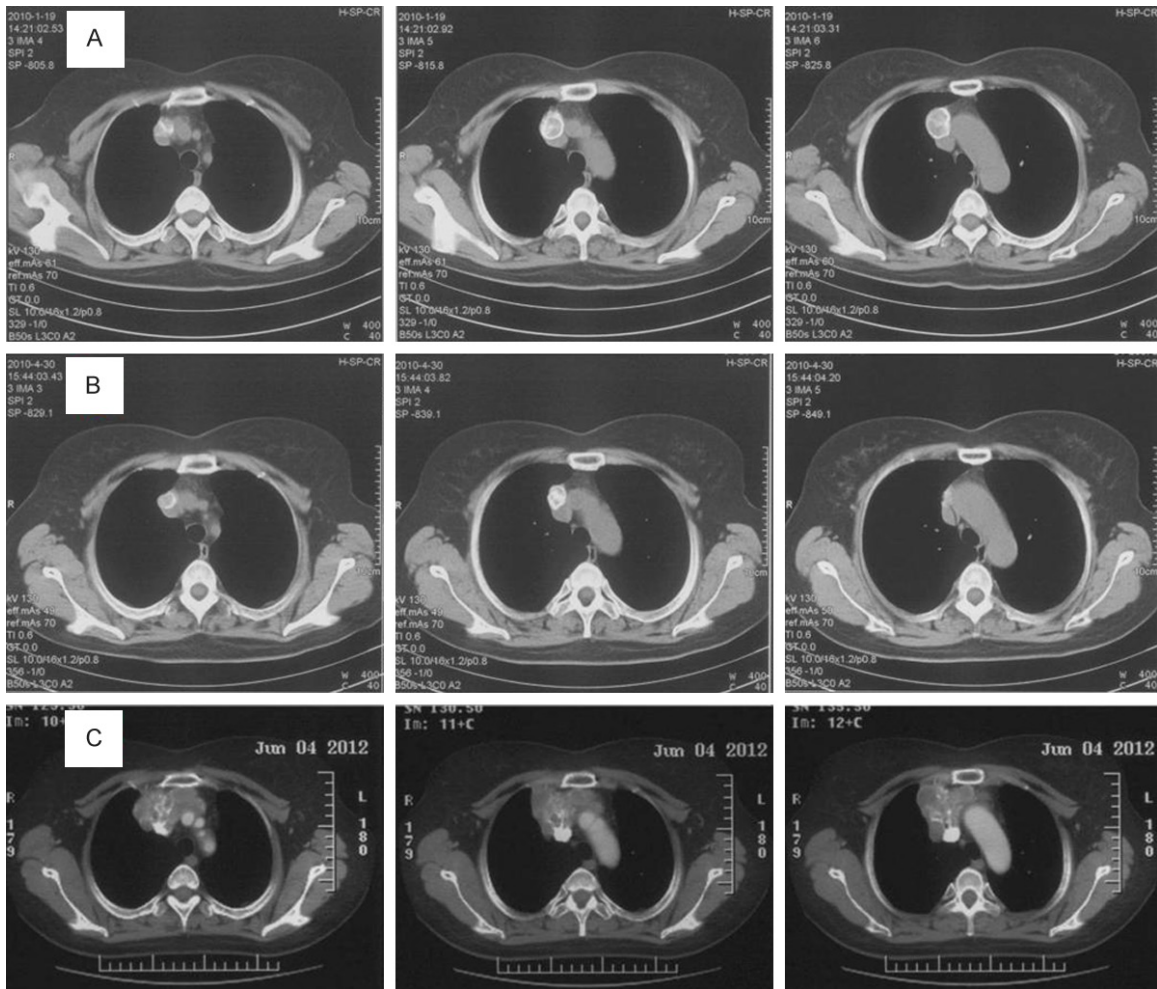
A. Computed tomography (CT) from January 19, 2010, showing a nodule with rim- and linear calcifications. B. CT from Apr 30, 2010, showing a smaller, denser, calcified nodule. C. CT from Jun 4, 2012, showing a soft-tissue mass with punctate calcifications in the superior mediastinum, invading the superior vena cava.
